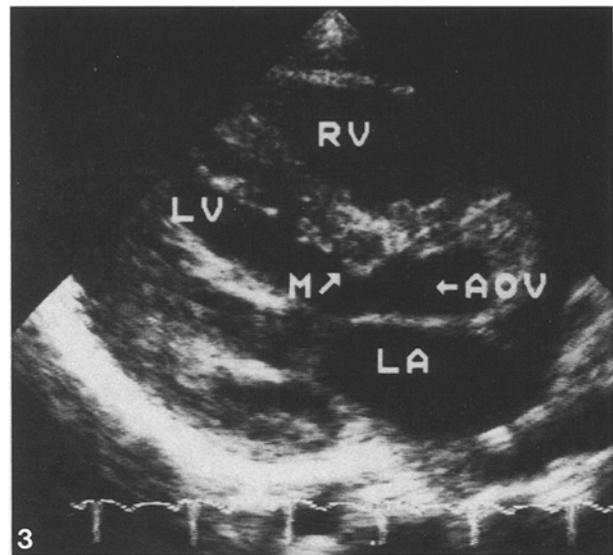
Case 1, two-dimensional echocardiogram recorded in the parasternal long axis plane. In this diastolic frame, the left ventricular outflow tract (LVOT) is free of extraneous echoes. The aortic valve (AoV) is thickened. LA, left atrium; LV, left ventricle; RV, right ventricle.
